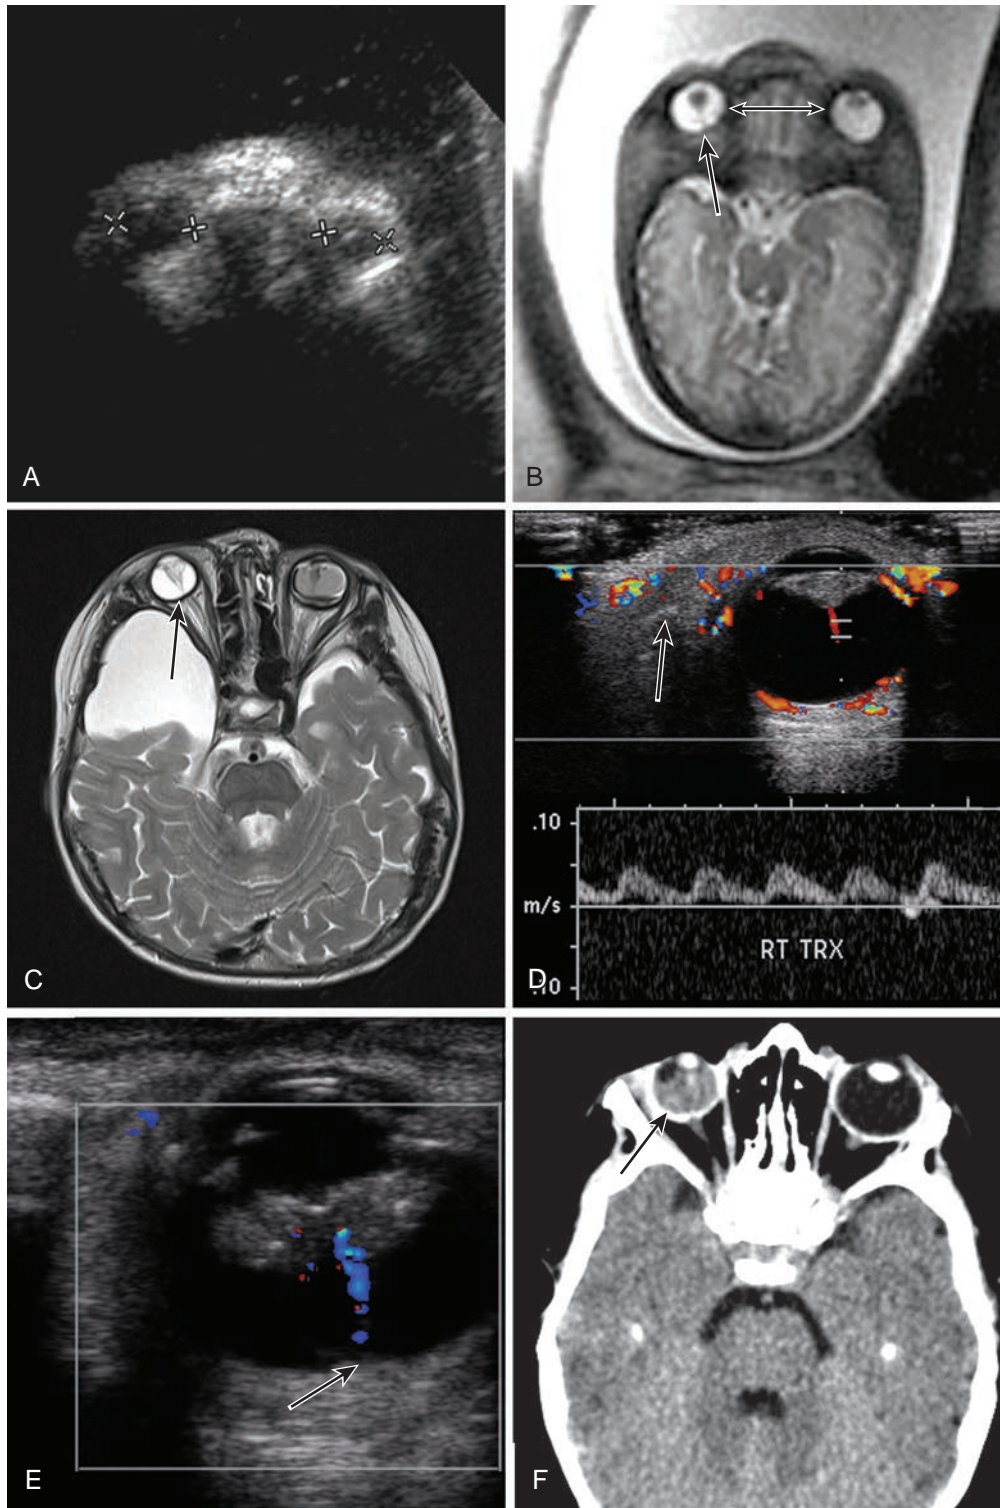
Persistent hyperplastic primary vitreous. (A) Fetal ultrasonography shows the absence of normal anatomy and ocular hyperechogenicity. (B) Fetal MRI shows hypertelorism (*double-headed arrow*) plus a persistent hyaloid artery (*large arrow*) and a triangular-shaped lens. (C) Postnatal axial T2-weighted MRI demonstrates a low funnel-like signal extending from the right posterior lens to the optic nerve head (*arrow*). A similar low signal is noted on the left with associated vitreous hemorrhage. Note the incidental right middle cranial fossa arachnoid cyst. (D) Doppler ultrasound reveals an arterial waveform within the hyaloid artery (*arrow*). (E) Ultrasound shows thickening of the soft tissues posterior to the lens and a hyaloid vessel (*arrow*). (F) Axial noncontrast CT image shows increased attenuation in the right posterior chamber in keeping with vitreous hemorrhage (*arrow*) with linear high density centrally in persistent hyperplastic primary vitreous.
